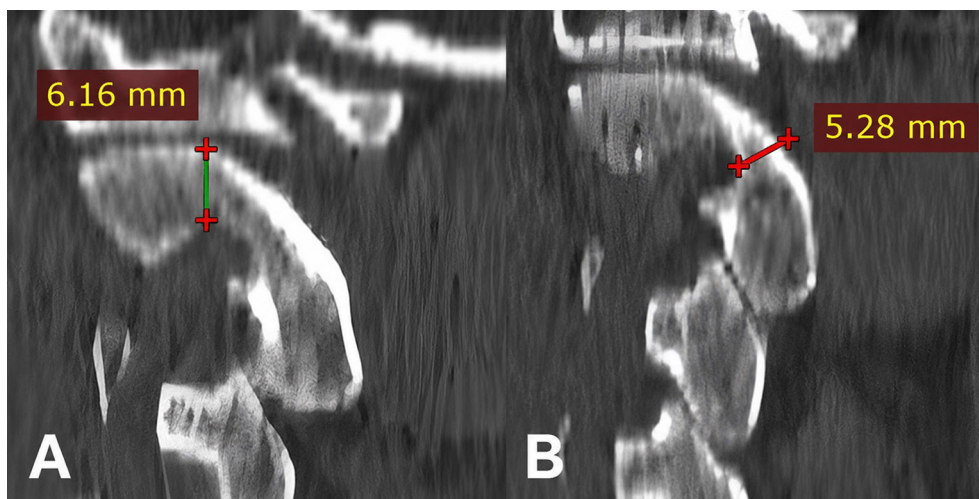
Axial CT measurement of C1 lateral mass dimensions.
